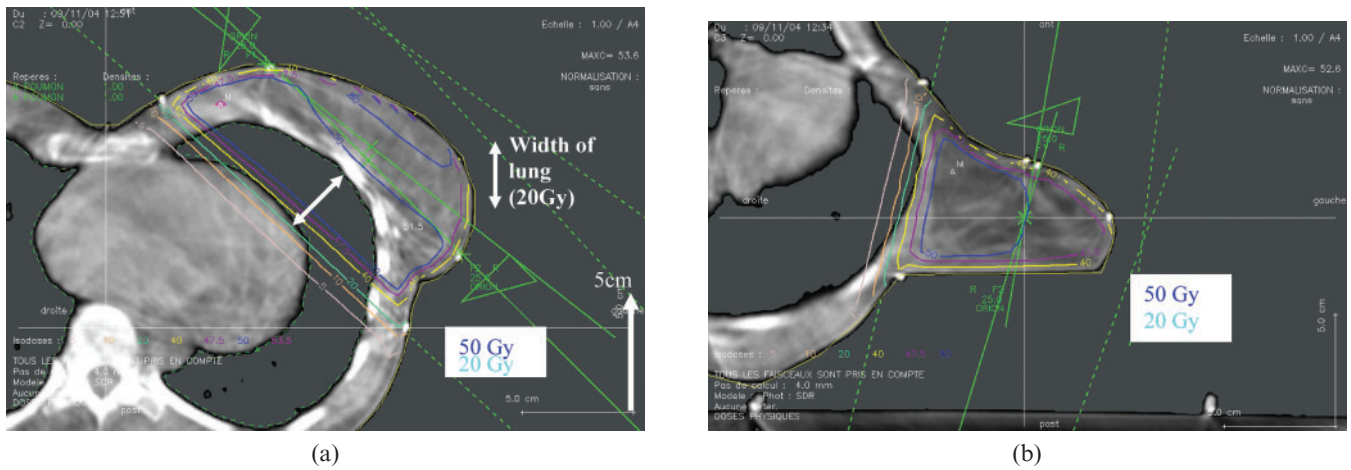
CT-scan slices at the level of the central axis ($z=0$) of the same patient with pectus excavatum taken in (a) the supine and in (b) the lateral decubitus set-ups. Dosimetry of whole-breast radiotherapy was made for a prescribed dose of 50 Gy at mid-thickness using 4 MV photons.
